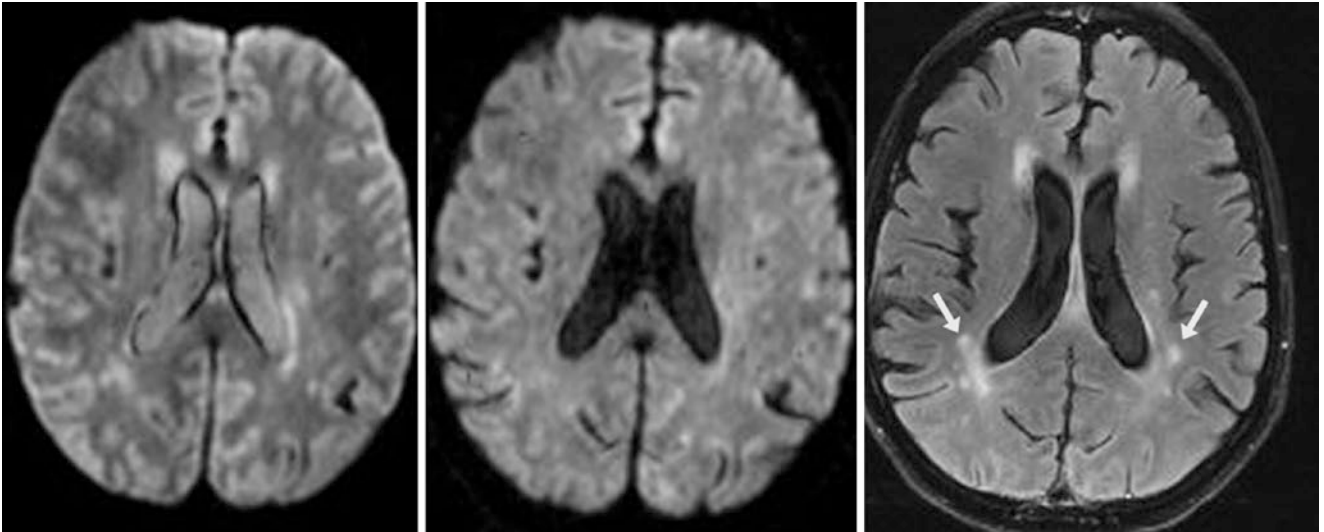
A 59-year-old with a 1.5 T MRI had DWI that utilized b values of 500 (*left*) and 1000 (*middle*) s/mm^2 . FLAIR images (*right*) show the classic T2 hyperintensities of chronic small vessel ischemic
